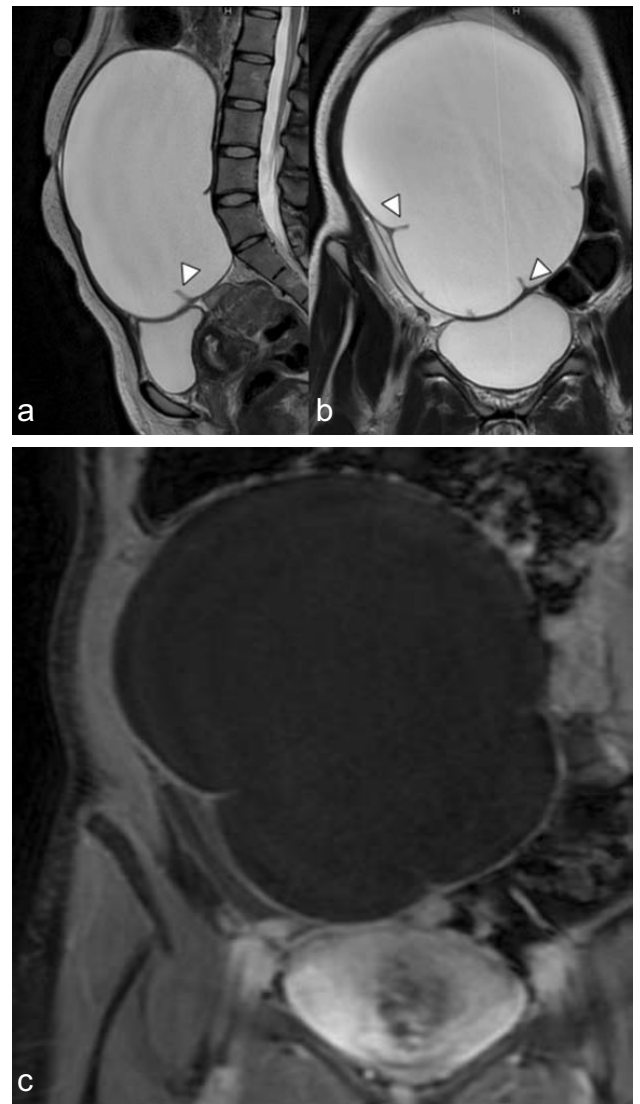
T2-weighted sagittal and coronal MRI show a hyperintense lesion with incomplete internal septations (arrowheads). c: T1 fat-sat post-contrast MRI shows hypointense signals without an enhancing solid component.
